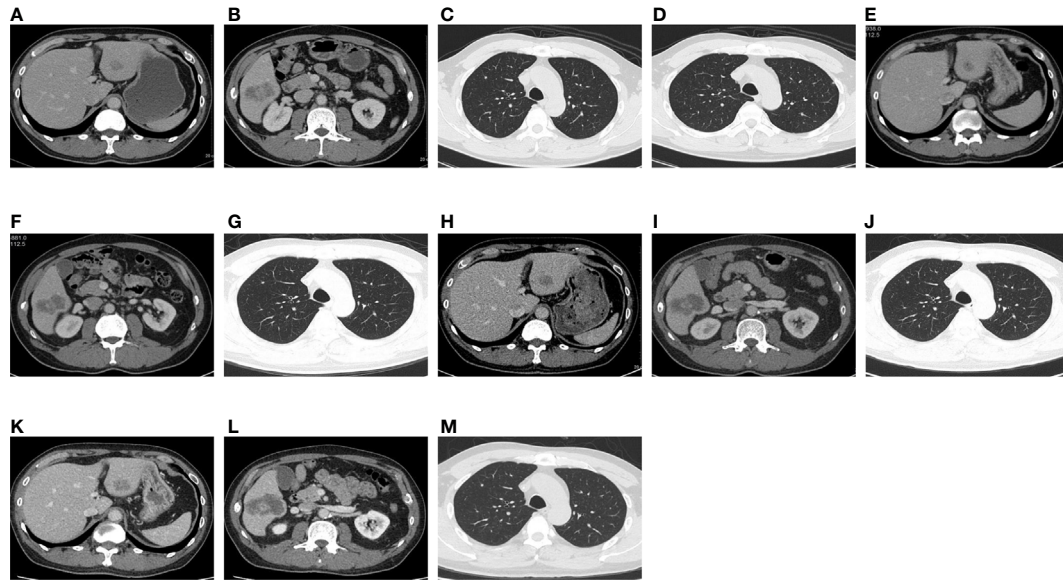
On December 18, 2019, CT showed hepatic S3 metastases with a long diameter of 1.8 cm (A), hepatic S6 metastases with a long diameter of 4.4 cm (B), right upper lung metastases with a long diameter of 0.3 cm (C), and a metastatic tumor of left upper lung, with a long diameter of 0.25 cm (D). On April 3, 2020, CT showed hepatic S3 metastases with a long diameter of 1.4 cm (E), hepatic S6 metastases with a long diameter of 4.5 cm (F), and right upper lung metastases with a long diameter of 0.3 cm (G). The original left upper pulmonary nodule was not shown. On June 6, 2020, CT showed hepatic S3 metastases with a long diameter of 2.1 cm (H), hepatic S6 metastases with a long diameter of 5.2 cm (I), and right upper lung metastases with a long diameter of 0.3 cm (J). The original left upper pulmonary nodule was not shown. On August 6, 2020, CT showed hepatic S3 metastases with a long diameter of 2.1 cm (K), hepatic S6 metastases with a long diameter of 5.5 cm (L), and right upper lung metastases with a long diameter of 0.3 cm (M). The original left upper pulmonary nodule was not shown.
